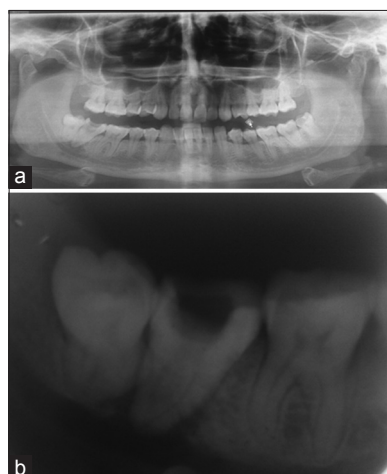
(a) Preoperative orthopantograph showing periapical pathology with respect to carious 47 and impacted 48. (b) Preoperative intraoral periapical showing periapical pathology with respect to carious 47 and impacted 48
